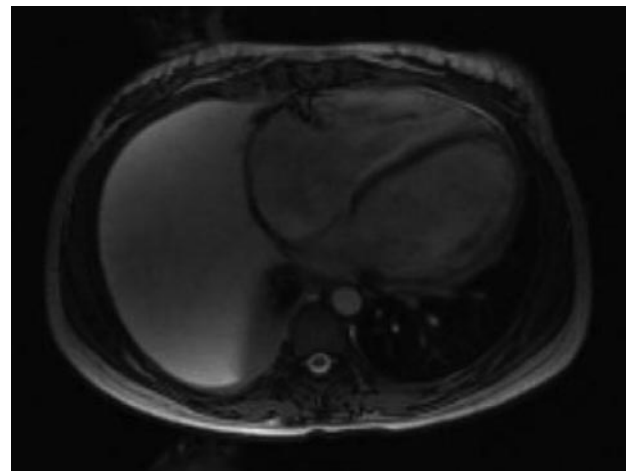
Cardiac MRI (transverse view, steady-state free-precession sequence) in a young African woman 2 months after delivery demonstrates marked dilation of both ventricles and the right atrium. LVEF is 8%.
